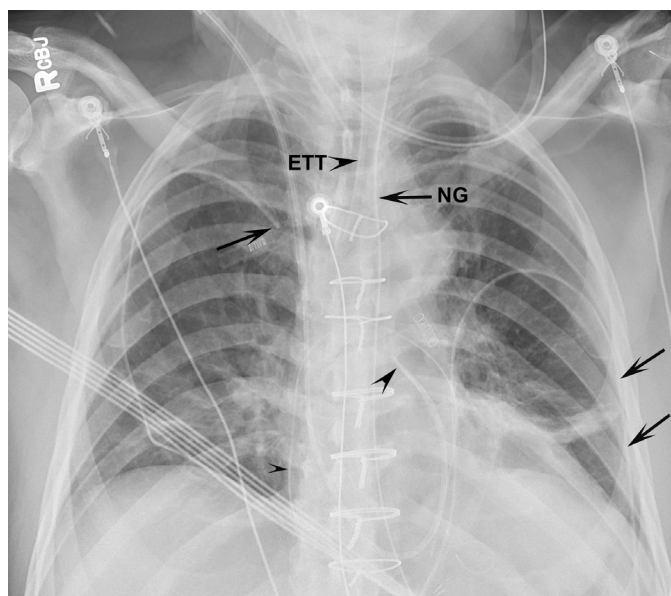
■ Anteroposterior (AP) supine chest x-ray. Immediate postoperative coronary artery bypass graft chest x-ray with classic left lower lobe atelectasis, partially obscuring the left heart border and the left hemidiaphragm. Endotracheal tube (ETT), nasogastric tube (NGT), bilateral chest tubes (*black arrows*), and Swan-Ganz catheter (*black arrowhead*) are all in a good position.
